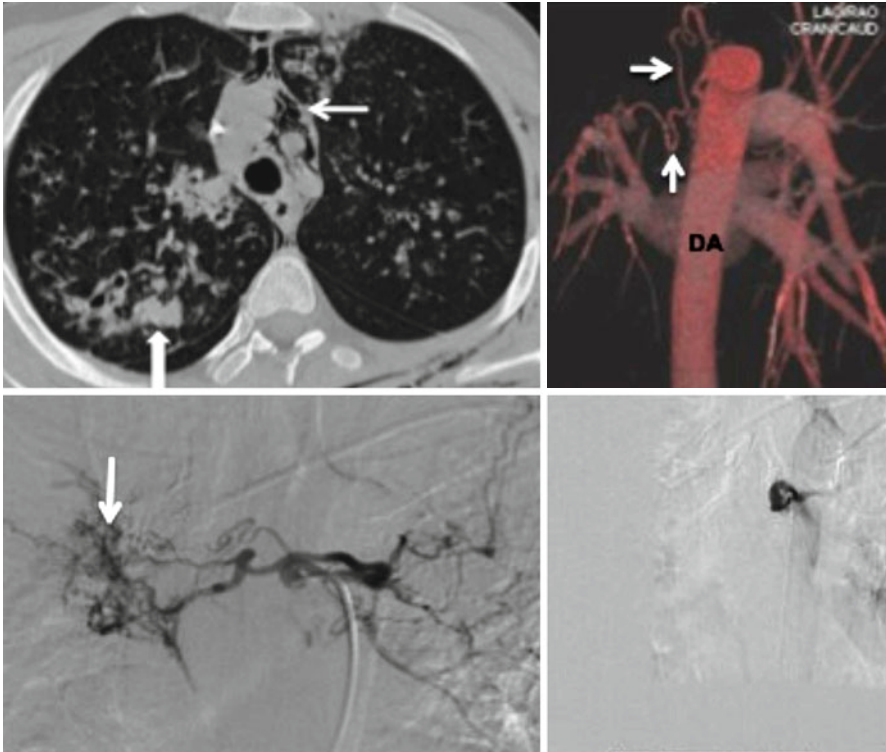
A 18-year old male cystic fibrosis patient with hemoptysis. CT (*top left*) demonstrates widespread bronchiectasis with focal area of hemorrhage in the right lung (*block arrow*) and pneumomediastinum (*thin arrow*). Volume rendered technique CT image (*top right*) elegantly demonstrates the enlarged bronchial collaterals (*thin arrows*) arising from the descending aorta (DA). Catheter angiography was performed to identify the culprit lesion (*white arrow*) (*bottom left*) that was subsequently successfully embolised (*bottom right*)
